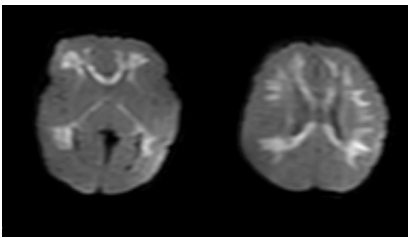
Bilateral symmetrical diffuse restricted diffusion in periventricular white matter with involvement of corpus callosum on DWI.
